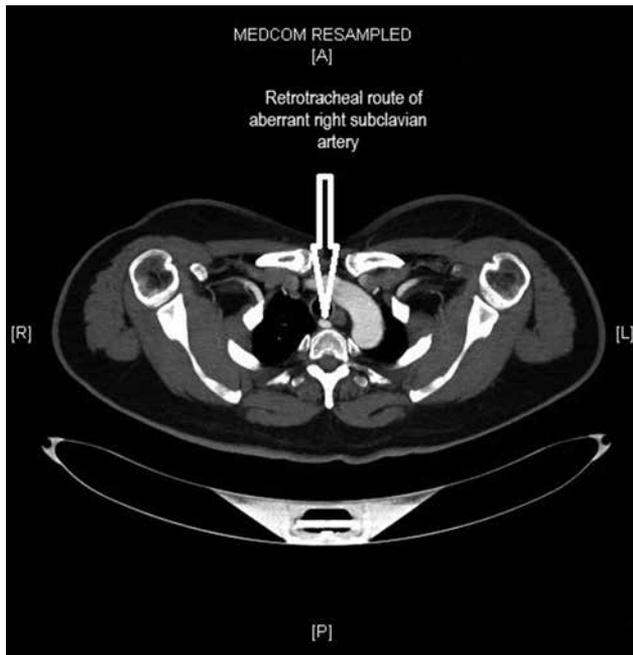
Retrotracheal route of aberrant right subclavian artery on contrasted computed tomography; sagittal section.
